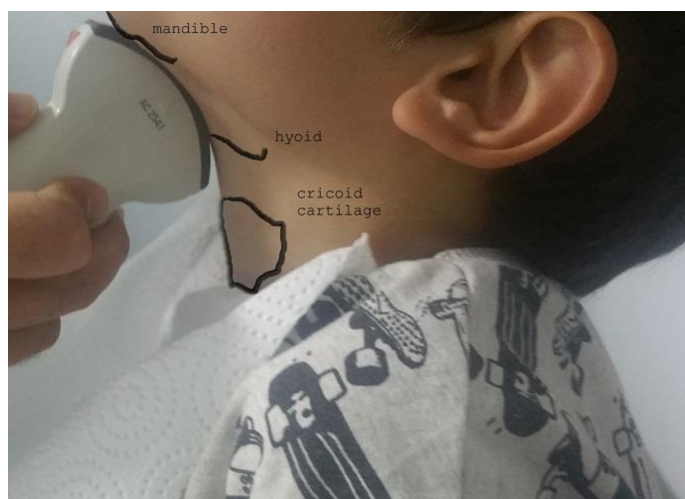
During the ultrasound (US) examination, the participant was in a sitting position. The anatomical landmark relationship with the transducer placed under the chin is shown.
